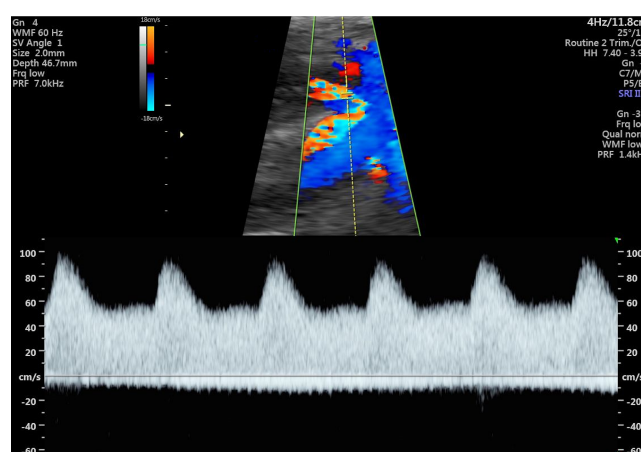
Doppler images with waveform from uterine artery obtained transabdominally in third trimester.
